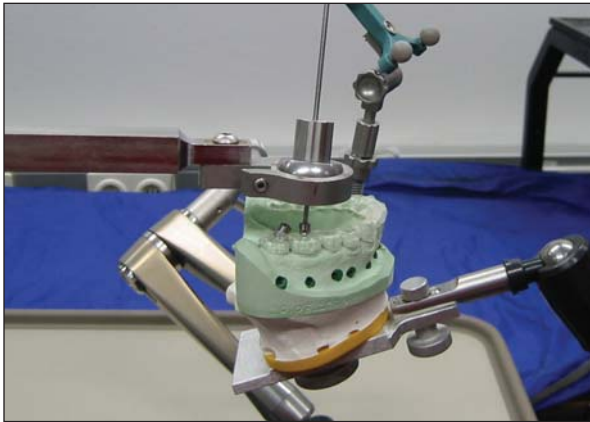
Laboratory setup for registration and navigation: A = base plate; B = mechanical arm for the fixation of the dental stone cast by the dental articulator's fixation system; C = EasyTaxis aiming device; D = reference arc. For registration, the mouthpiece with the registration frame attached was mounted to the fixed dental stone cast. By touching the registration markers with the navigation probe, the "virtual" (CT-data) markers were linked to the corresponding "real" (setup) markers, which allowed the transfer of the 3D surgical plan to the dental stone cast.
